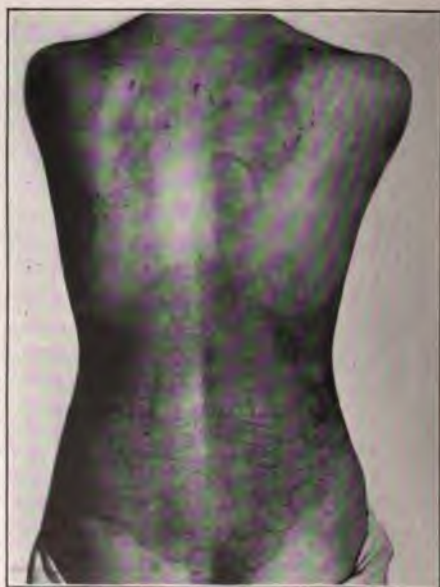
Same patient shown in Fig. 131 after fractional x-ray treatment. The tanning is due to the disease.
